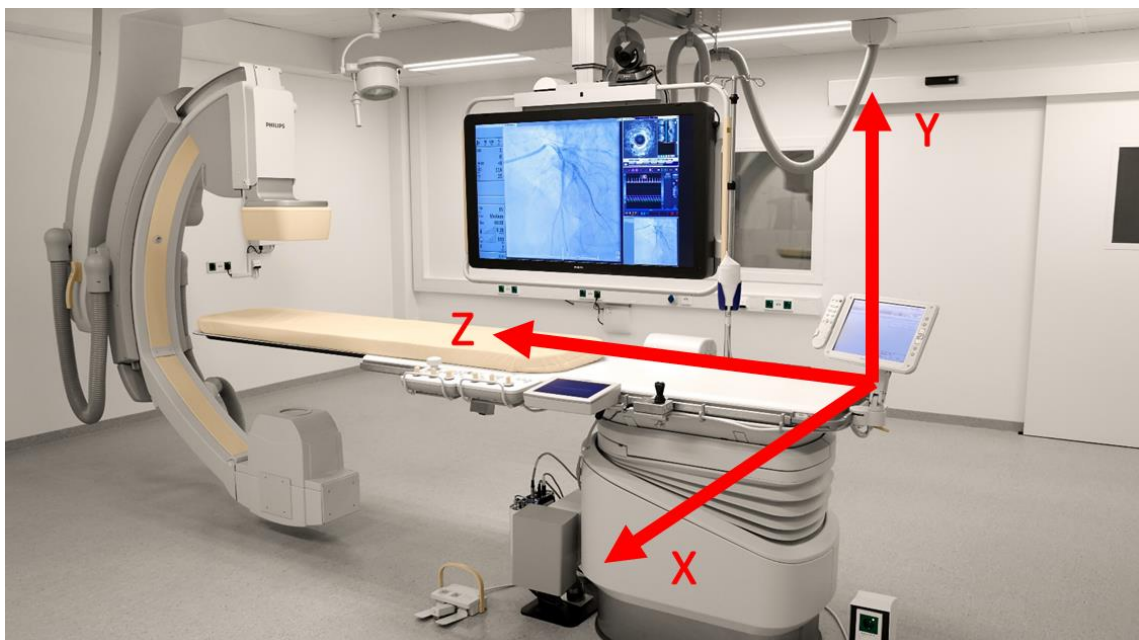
Patient reference system in real X-ray system
